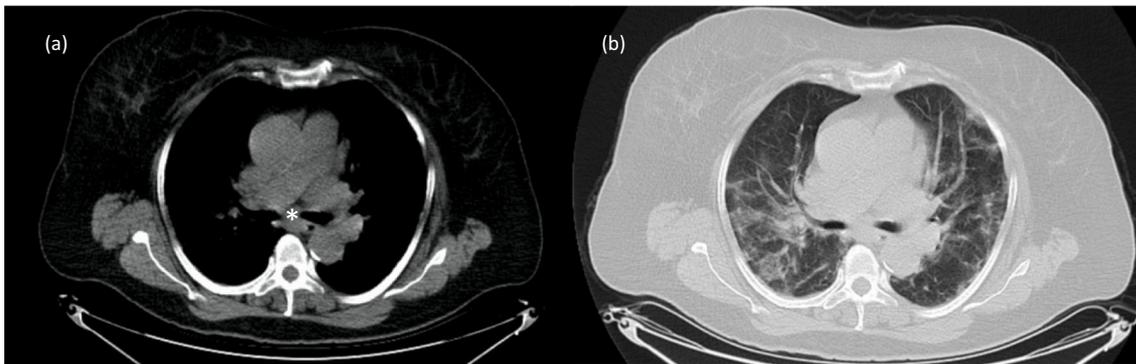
Axial unenhanced chest CT images of a 63 year-old woman with laboratory-confirmed COVID-19 pneumonia. (1a): Mediastinal window showing enlarged lymph node station 7 (1b): Lung window shows mainly peripherally located multiple patchy ground-glass opacities.
